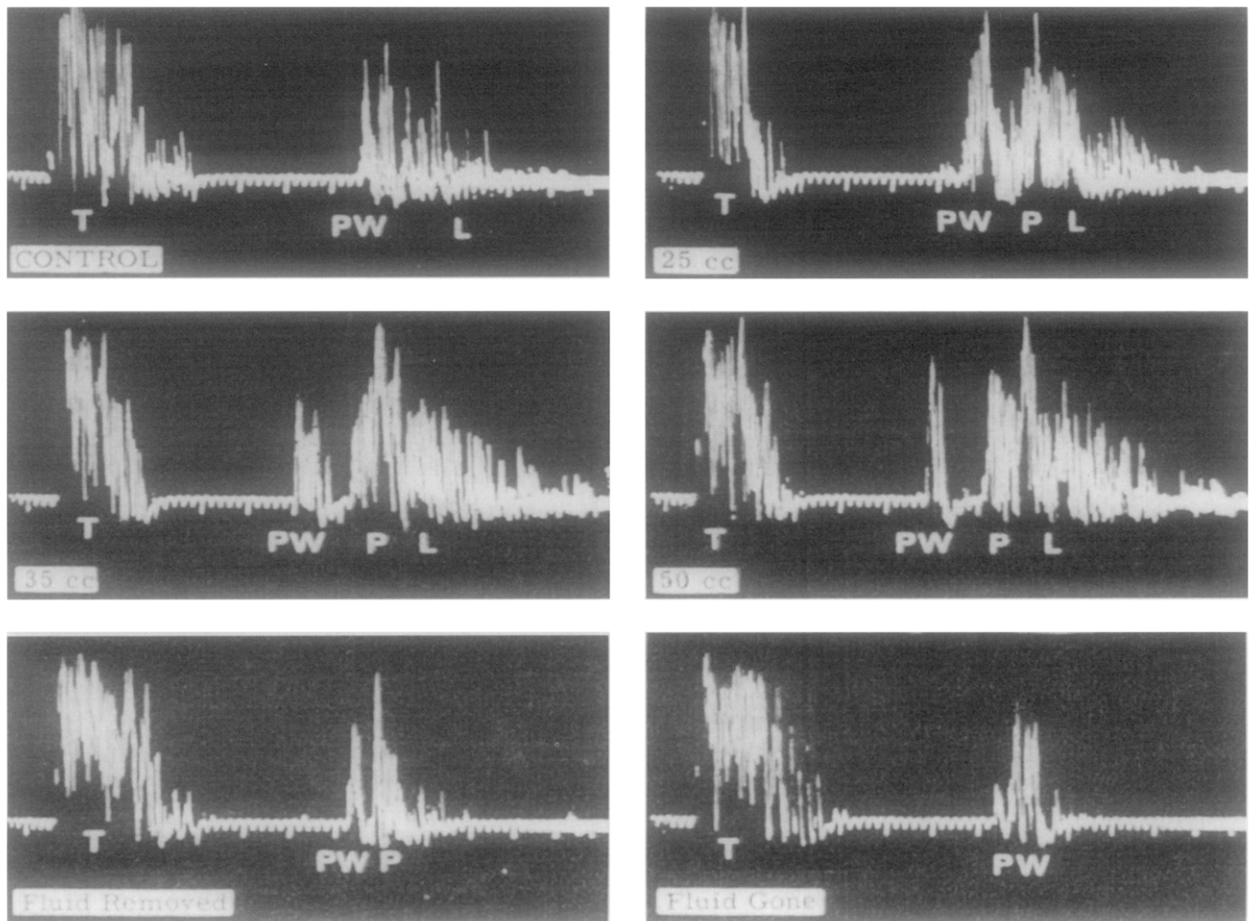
Canine experiment shows effect of injection of saline solution into pericardial sac on A-mode echocardiogram. With progressive instillation of fluid, there is separation of signals of the posterior wall (PW) of heart from posterior pericardium (P), which is anterior to lung (L) echoes. Note that posterior wall and pericardium fuse into single signal as fluid is removed. (T, Transducer signal.) (From Feigenbaum H, et al. Ultrasound diagnosis of pericardial effusion. JAMA 1965;191:9;109.
